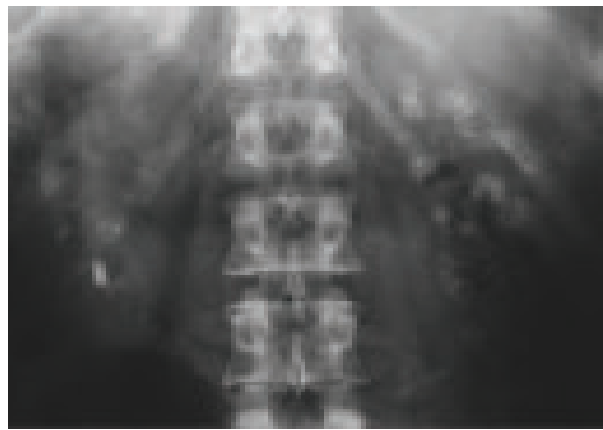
Plain X-ray KUB bilateral nephrocalcinosis
